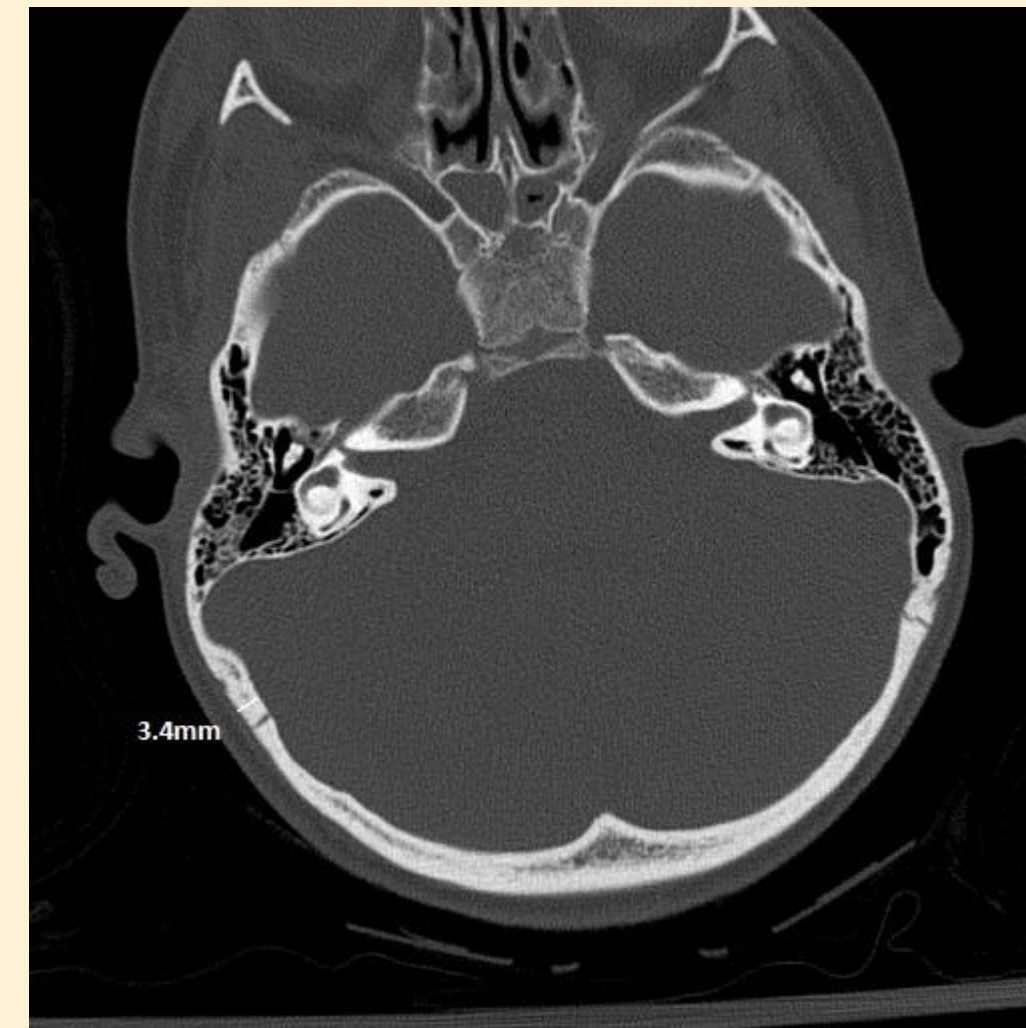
Temporal bone thickness measurement on axial CT.
